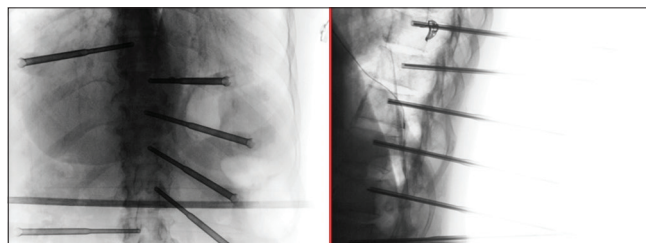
Intraoperative two-dimensional scan (AP and LL) with cone-beam computed tomography showing the position of the probes within the involved level
